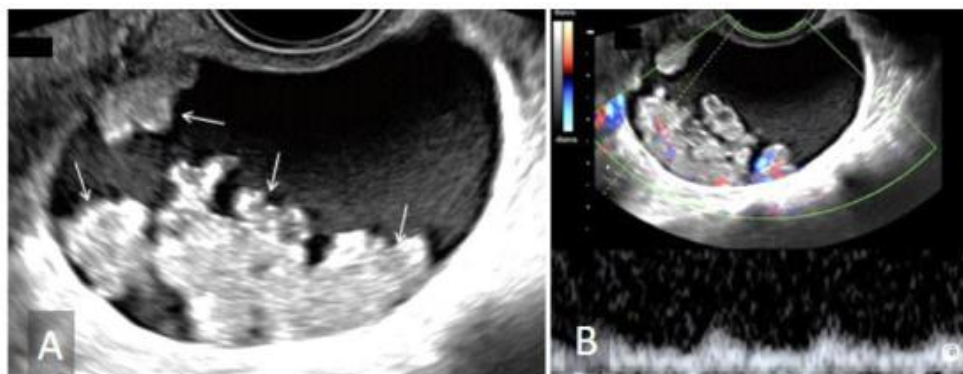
Transvaginal US of serous cystadenocarcinoma of the ovary. Note the presence of multiple papillary projections in A (arrows) and in B, color and pulsed Doppler shows vascularity within the papillary projections (20).
